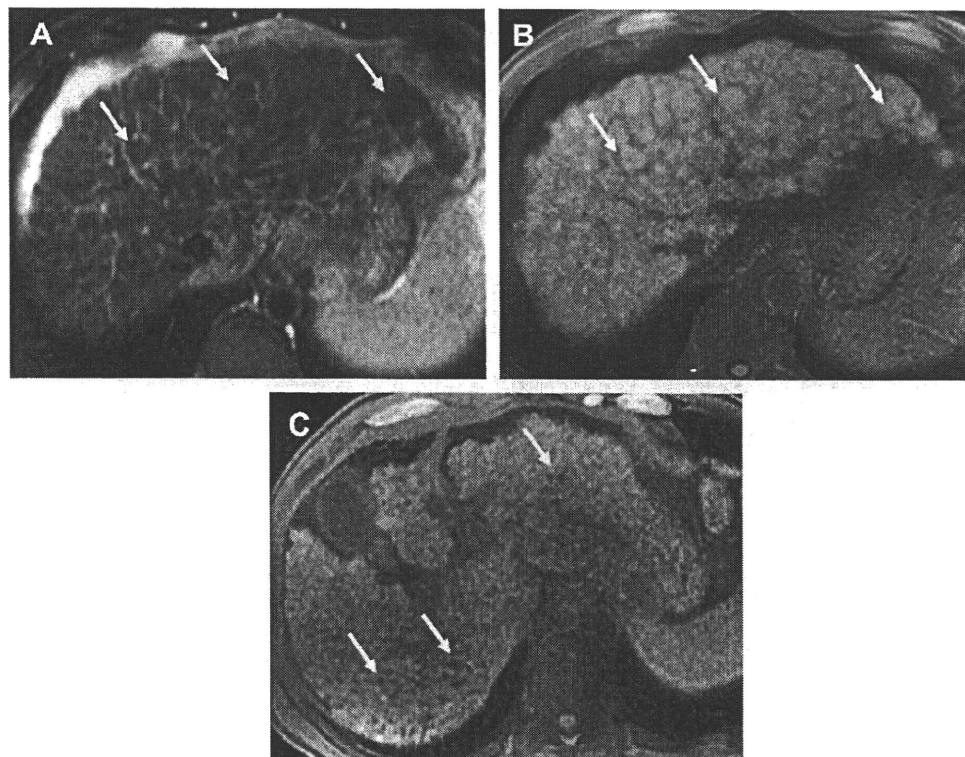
Innumerable regenerative nodules have varying signal intensity, appearing isointense to hypointense on a T2-weighted fat-saturated TSE image (A) (arrows) and isointense to hyperintense on a T1-weighted fat-saturated 3D GRE image (TR/TE = 3.6/1.7 ms, flip angle = 15°) (B) (arrows). Hemosiderin deposition is common in regenerative nodules (siderotic nodules), producing such specific imaging features as hypointensity on T1-weighted fat-saturated 3D GRE image (C) (arrows).
